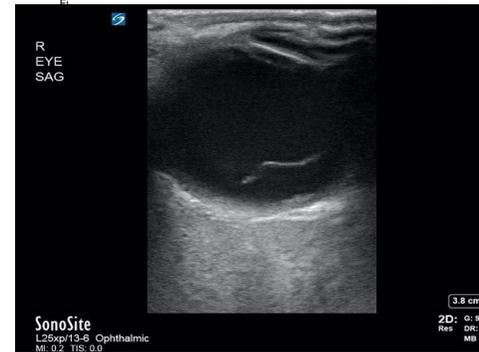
Point of care ultrasound (POCUS) demonstrating a hyperechoic linear abnormality floating in the vitreous humor in the patient's affected eye--consistent with RD.
